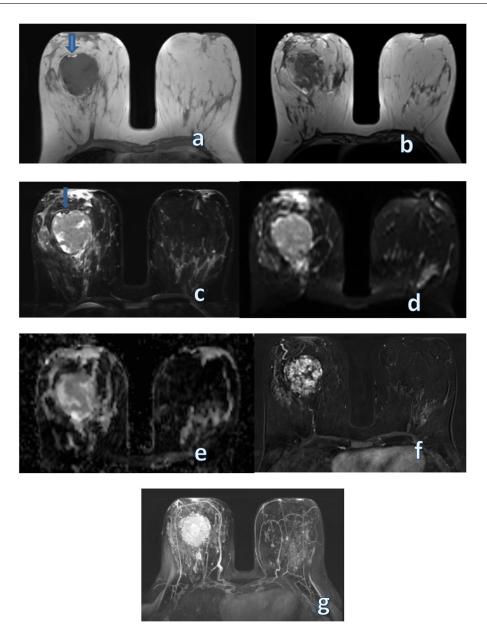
Axial T1WI spin echo nonfat-suppressed unenhanced image (TR/TE, 260/2) shows a rounded shape, circumscribed mass with predominant low signal intensity and fine streak of high SI at most anterior part (arrow) (a). Axial nonfat-suppressed fast spin echo T2-weighted MRI (TR/TE, 4800/79) shows a mass with mixed signal intensity (b). Axial STIR images shows the mass with mixed signal intensity and thin streak noted anteriorly of fat suppression corresponding to high signal seen in T1WIs (arrow) (c). Axial DWIs (d) and ADC mapping (e) show no diffusion restriction. Axial dynamic contrast-enhanced fat-suppressed T1-weighted image shows intense heterogeneous enhancement (f) confirmed by dynamic contrast-enhanced maximum intensity projection (MIP) images (g).
